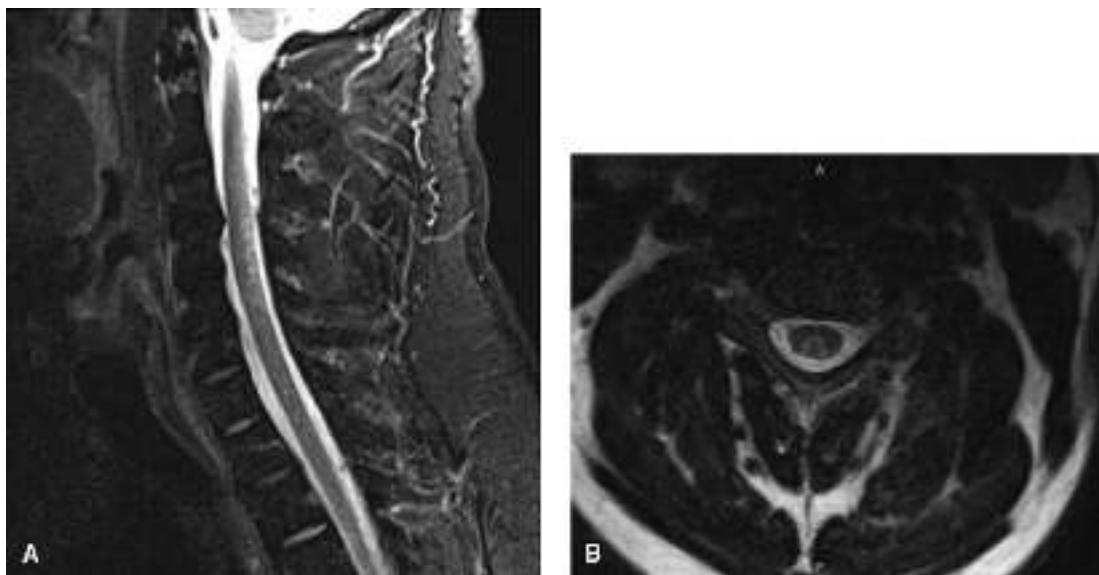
Nitrous oxide abuse myelopathy. Sagittal short T1 inversion recovery MRI showing hyperintensity in the posterior cervical and thoracic spinal cord (A); axial T2 hyperintensity (B). (Reprinted from Probasco JC, Felling RJ, Carson JT, et al. Teaching NeuroImages: myelopathy due to B_{12} deficiency in long-term colchicine treatment and nitrous oxide misuse. *Neurology*. 2011;77[9]:e51, with permission.)
